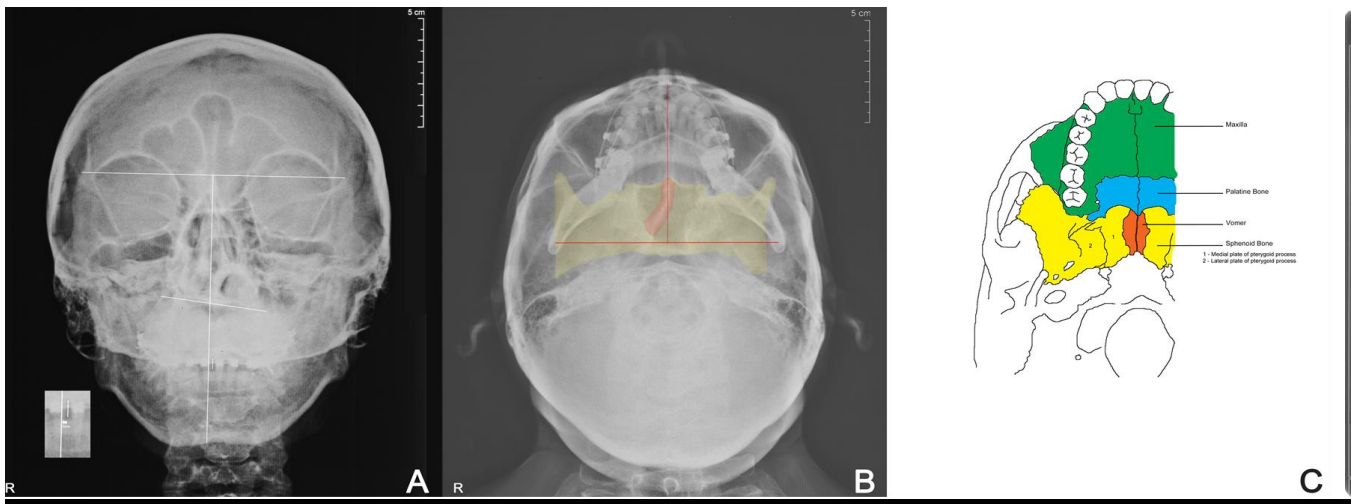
Radiographs of Subject 4 demonstrating posterior facial asymmetry.
